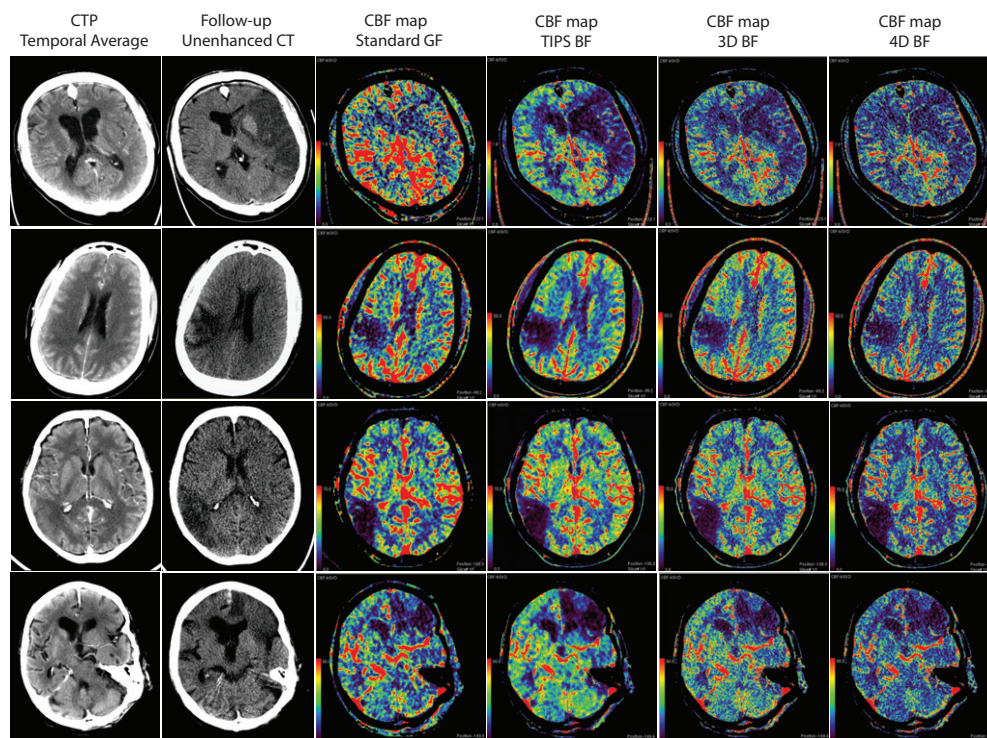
CBF maps of the selected slices of four of the fifteen filtered patient CTP scans used in the evaluation. In the observer study, the CBF maps were blindly presented to the observers in pairs, together with the temporal average of the original CTP scan (first column: reference for gray/white matter differentiation) and the follow-up unenhanced CT scan (second column: reference for infarction).
